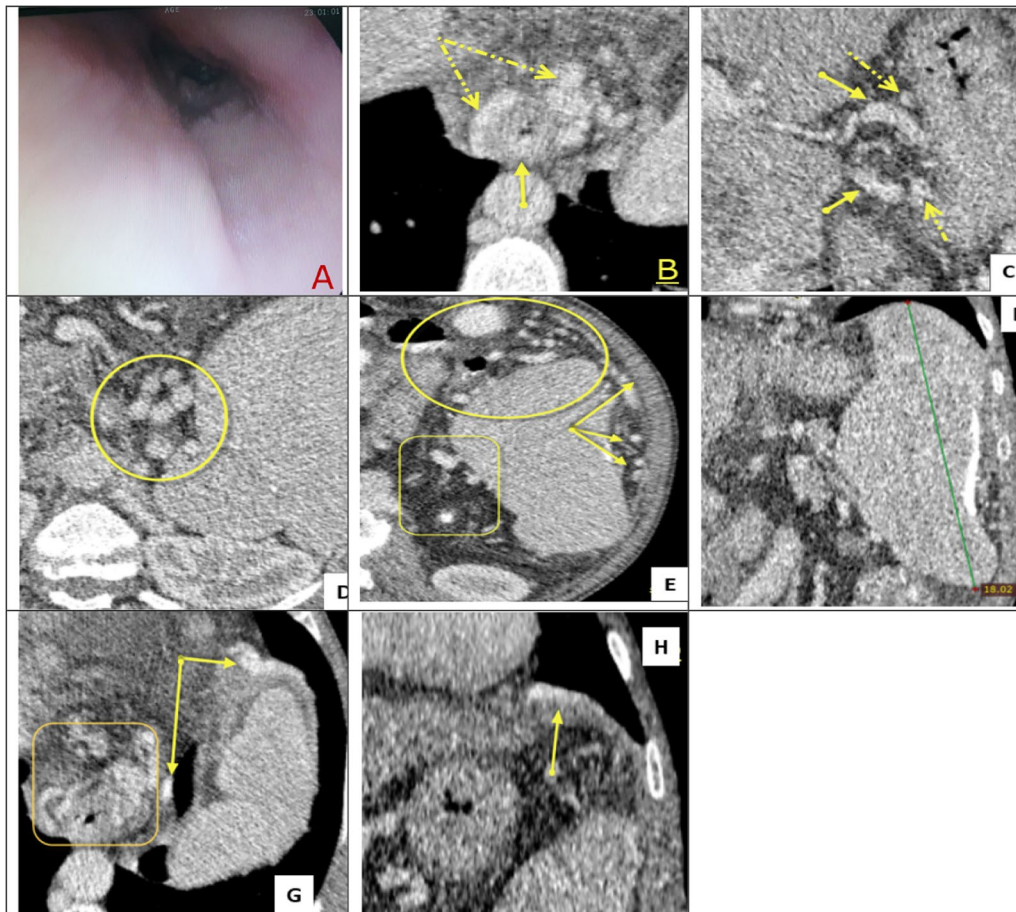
A 66-year-old male patient complained of chronic liver disease complicated by esophageal varices on follow-up with upper GI endoscopy. A Upper GI endoscopy shows obliterated esophageal varices. Axial CT shows; B no esophageal (obliterated) varices (solid arrow) but large tortuous paraesophageal varices (dashed arrows), C dilated tortuous left gastric (coronary) varices (solid arrow) and perigastric (adventitial) varices (dashed arrow), D perisplenic (hilar) collaterals (round region), E perisplenic collaterals with anterior border (round region), lateral border (solid arrows), and hilar (rectangular region). Coronal CT shows; F enlarged LS diameter of the spleen 18 cm. G Axial CT shows left supradiaphragmatic varices (solid arrows) and paraesophageal varices (rectangular region). H Coronal CT shows left supradiaphragmatic varices (solid arrow)
